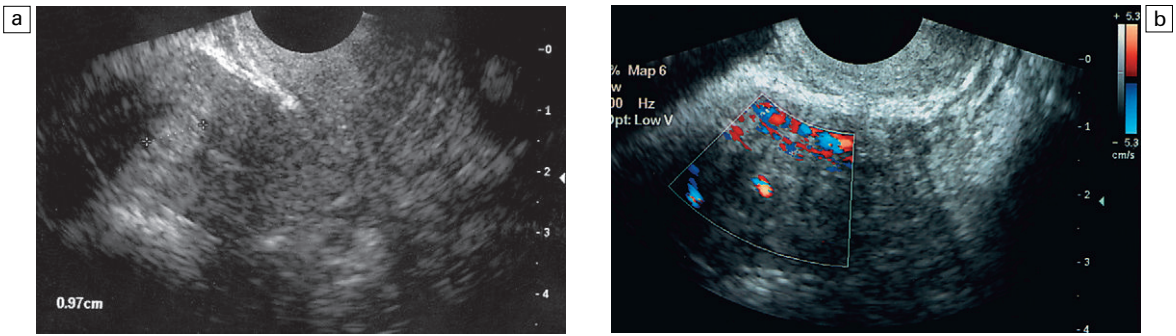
Endometrial polyp. (a) Transvaginal sonography demonstrates an echogenic lesion within the uterine cavity. (b) On colour flow Doppler there is a single vessel identifying the pedicle.
